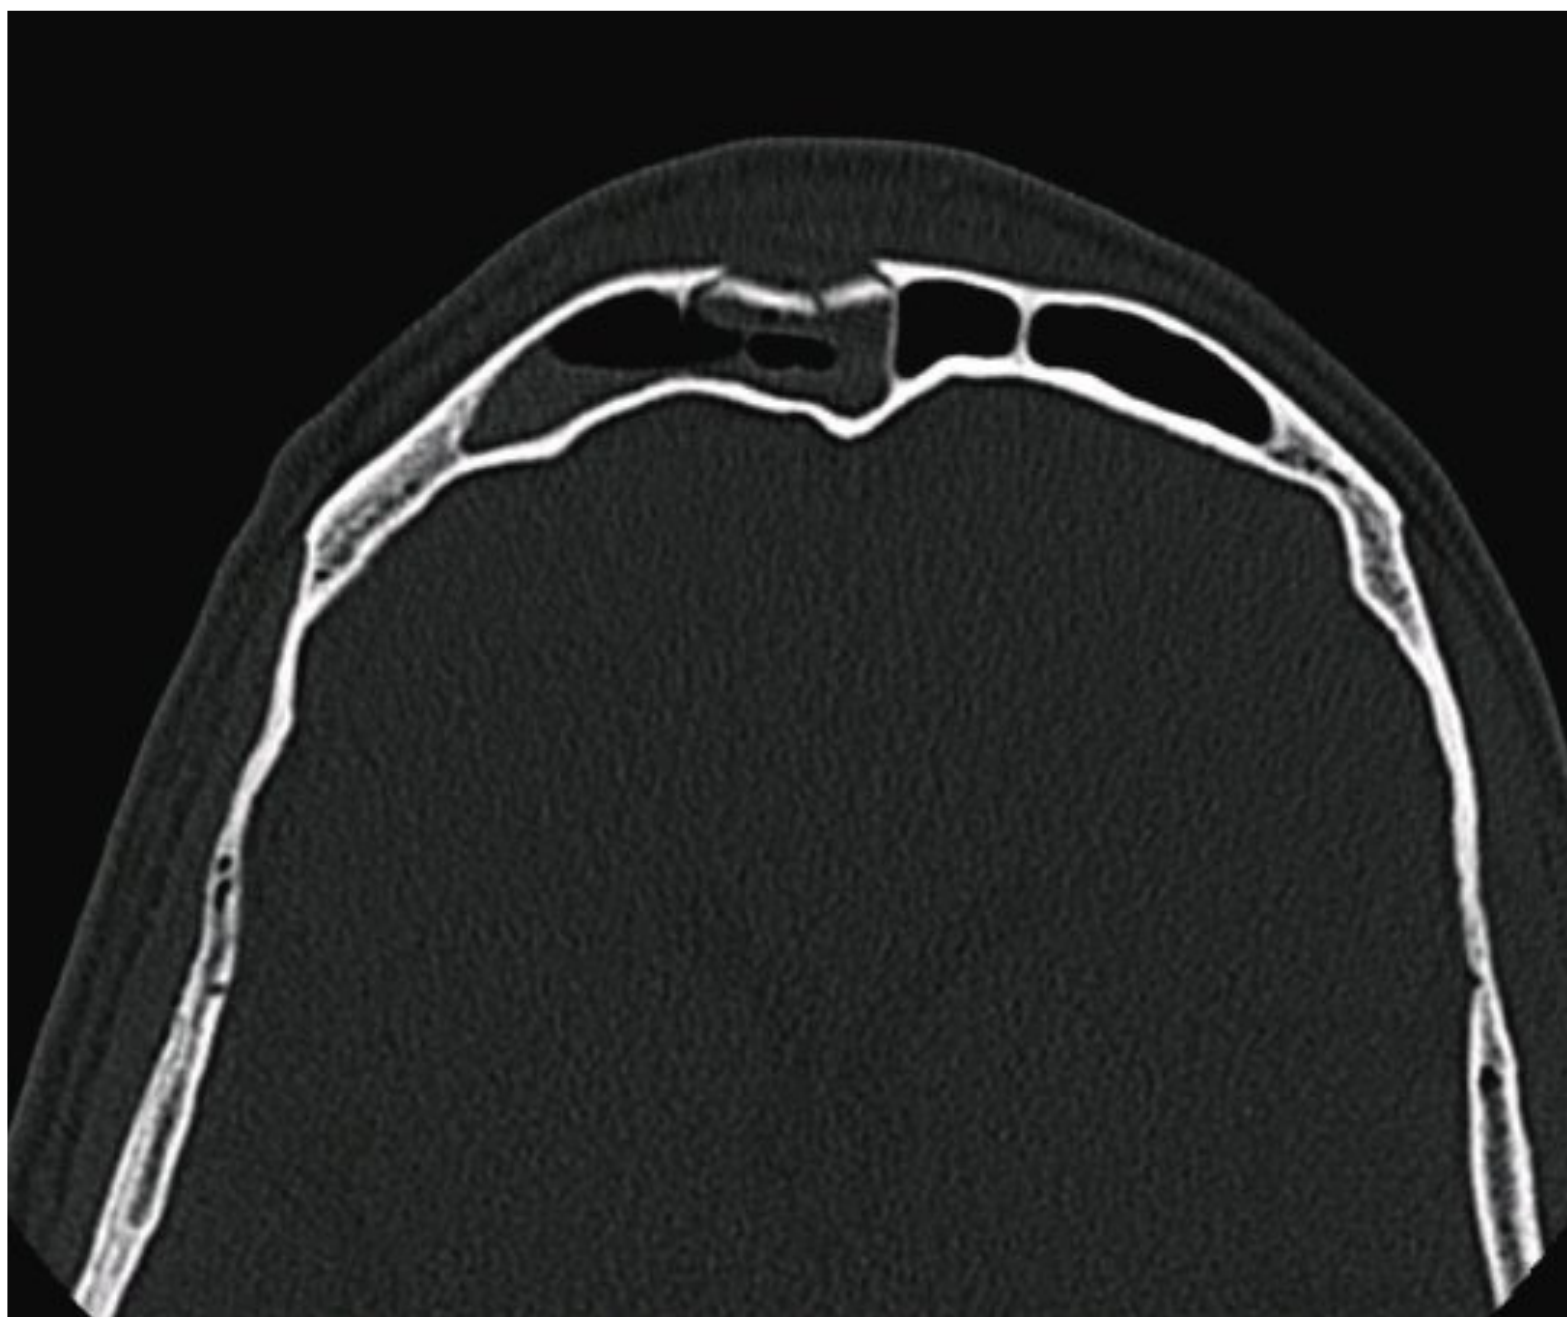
CT of anterior table fracture.
